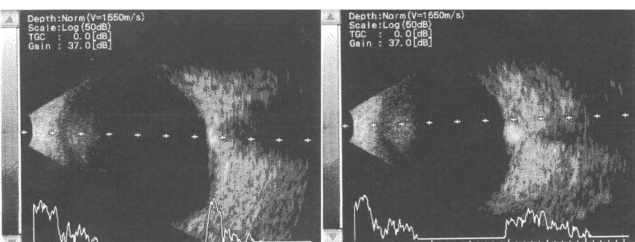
B-scan ultrasounds of both eyes. The optic nerve head have an area of hyperechoic reflections consistent with drusen
